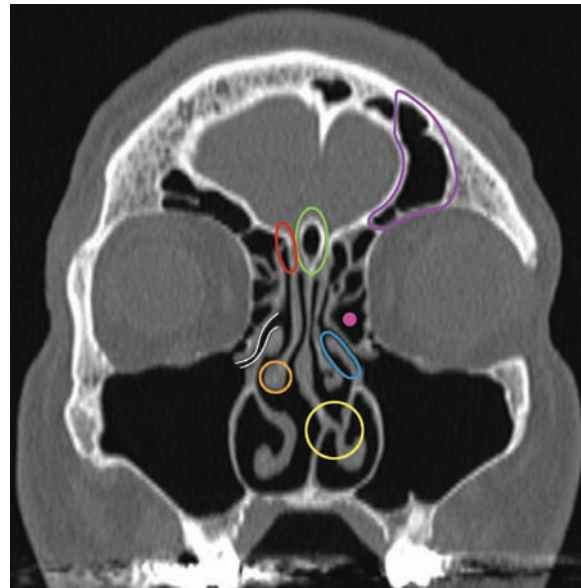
Coronal CT of the frontal sinus (FS) with mucosal swelling (gray) and isolated type IV frontal sinus cell on the subject's left-hand side (red circle). Notice the intersinus septal cell opacified at the midline (yellow) and the position of the anterior septal body (blue) and maxillary sinus (MS).
